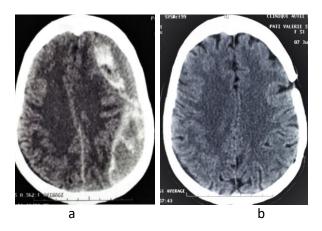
representative (a) pre operative CT scan and (b) post operative CT scan
